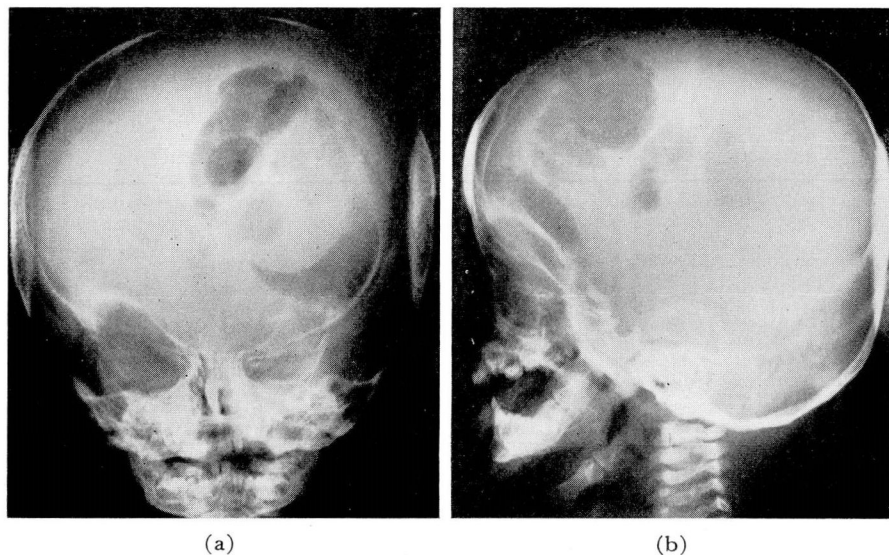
Roentgenograms after intracranial injection of air on left side showing bizarre bubble formation. Lower mass of air in anteroposterior view suggests outline of inferior surface of tumor.
